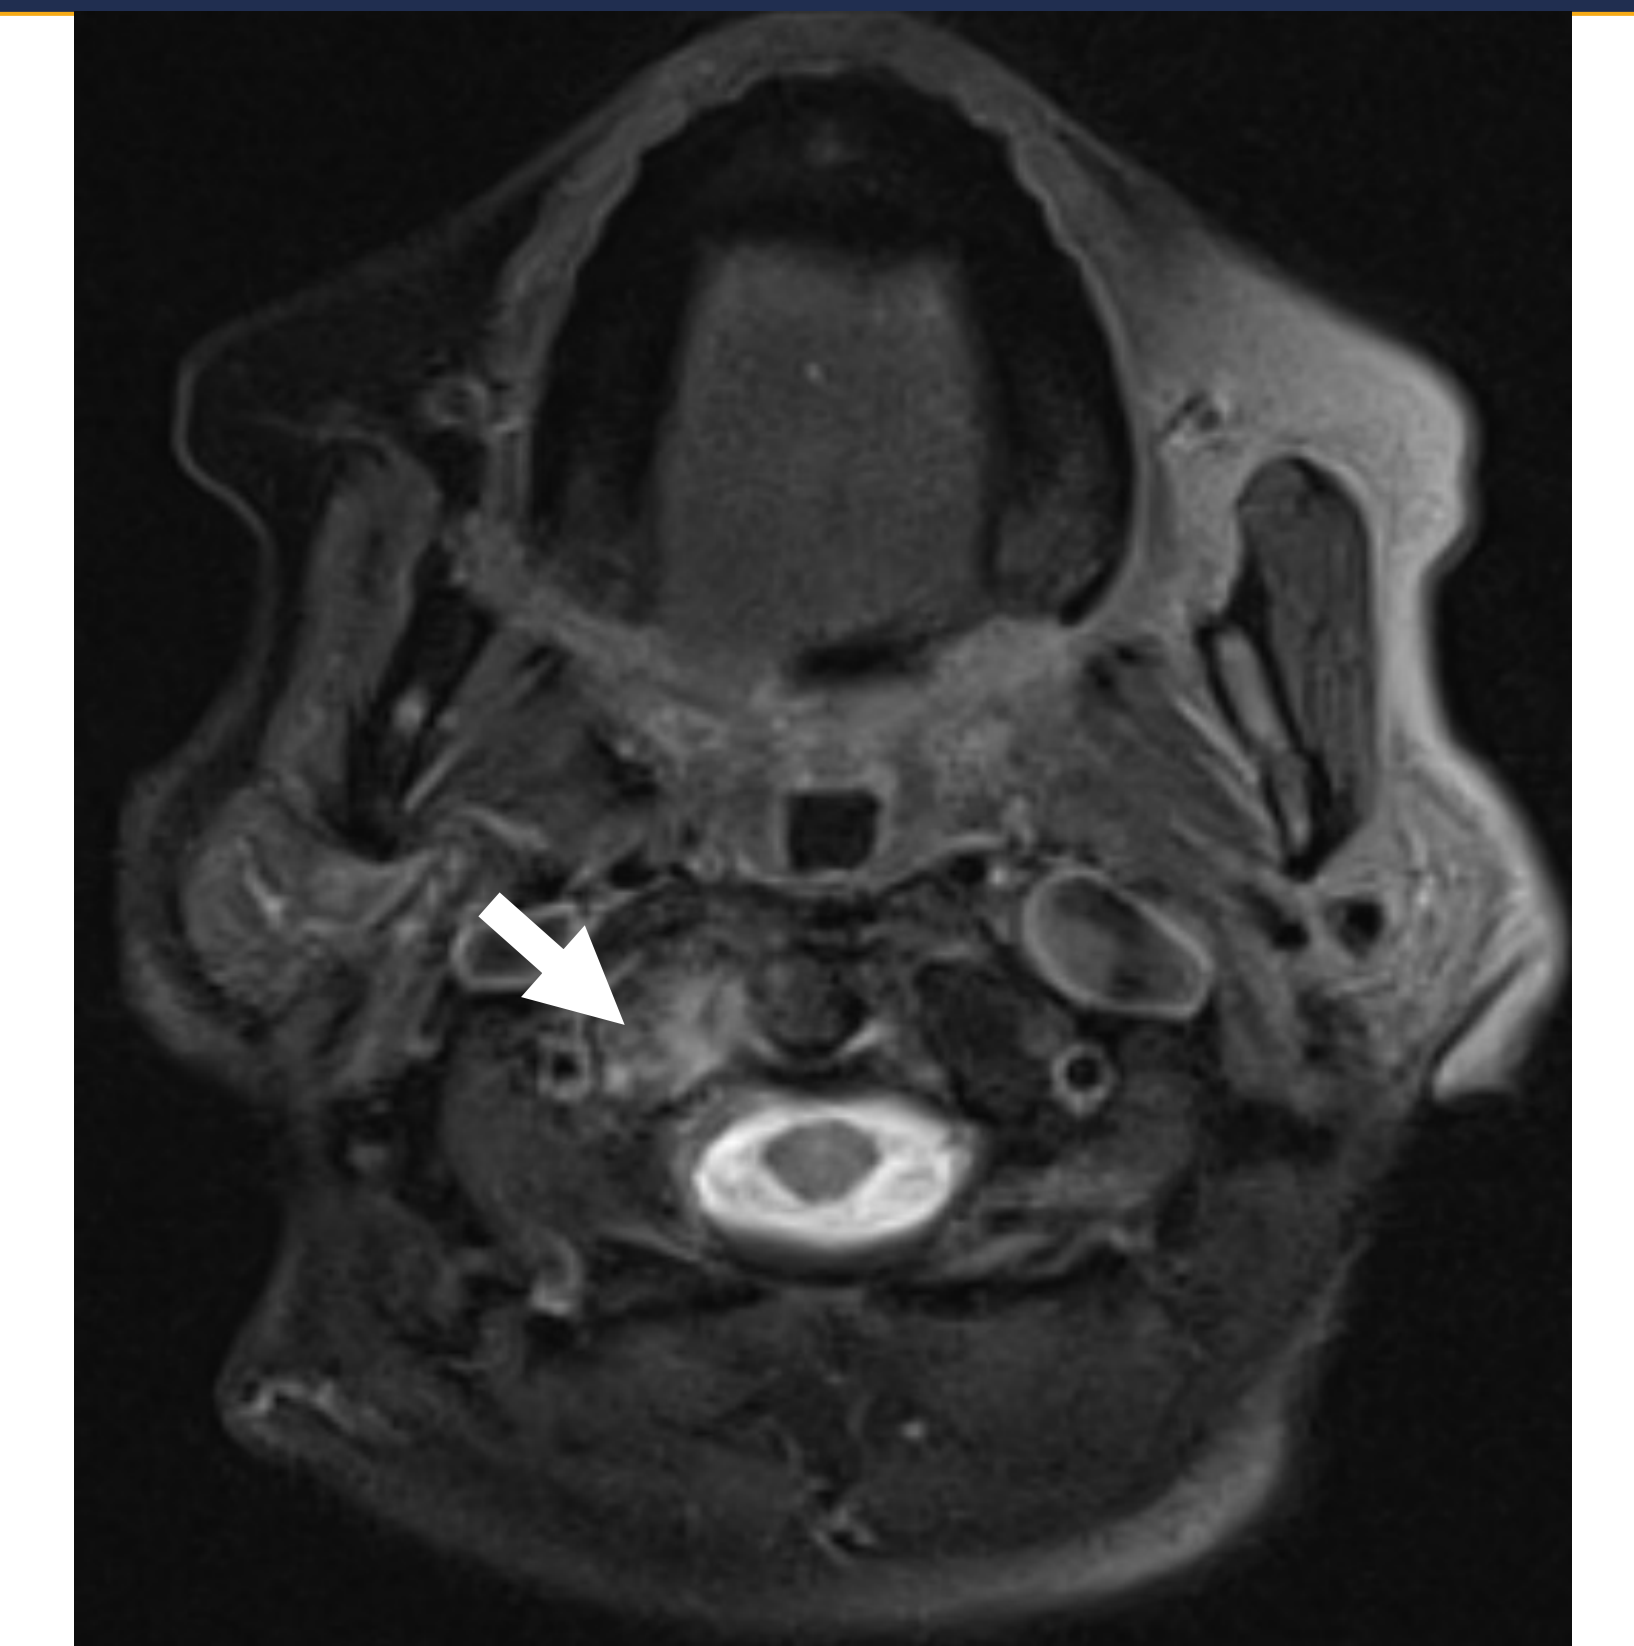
Axial T2W MRI demonstrating increased signal intensity at C1/C2 related to osteoarthritic changes. The rounding neuroradiologist determined that further MRI was unnecessary due to the known diagnosis of osteoarthritis. Imaging order was placed anyway and validated the neuroradiologist's recommendation.
